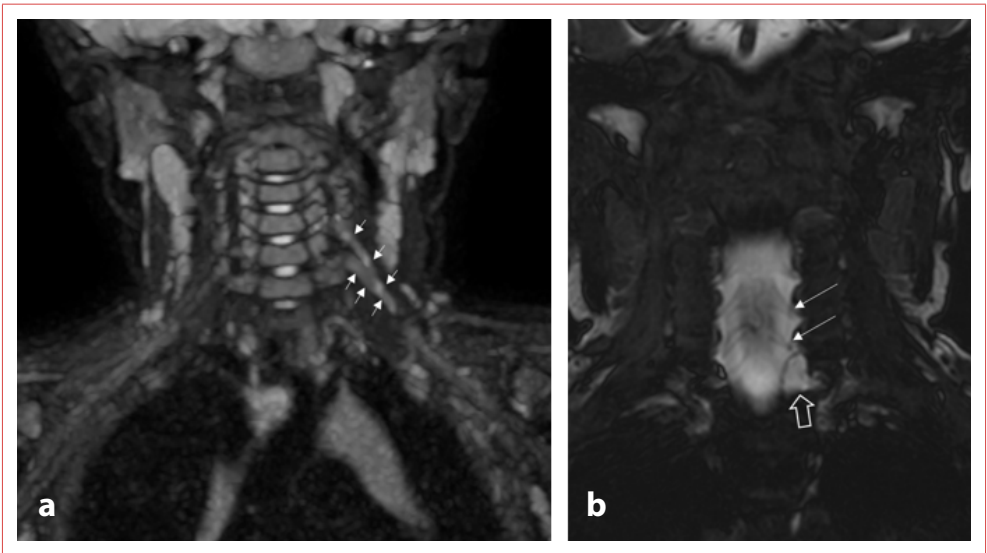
Mixed injury pattern in obstetric brachial plexus palsy. Coronal short T1 inversion recovery maximum intensity projection image (a) demonstrates asymmetric thickening and increased signal intensity of the left C5 and C6 roots at the interscalene level, consistent with postganglionic injury (small arrows). In the same patient, coronal heavily T2-weighted image (b) demonstrates intact left C5 and C6 roots (long arrow), whereas a left C7 root avulsion and associated pseudomeningocele (open arrow) are present, consistent with preganglionic injury.
